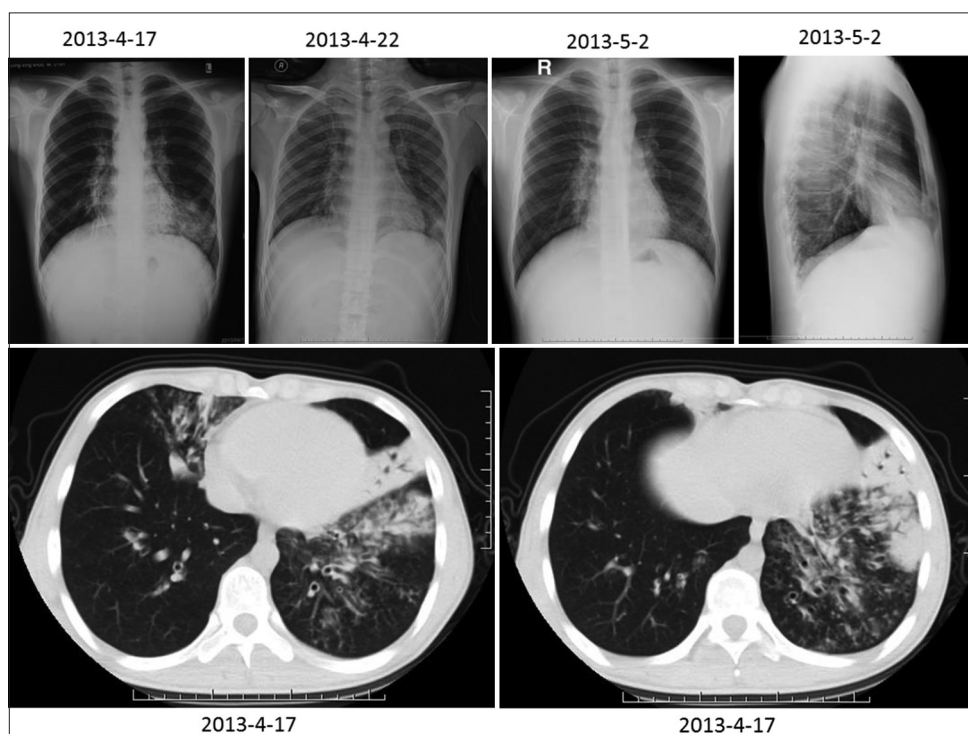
The chest X-ray and computed tomography of a patient with common variable immunodeficiency showed bronchiectasis with infection.
